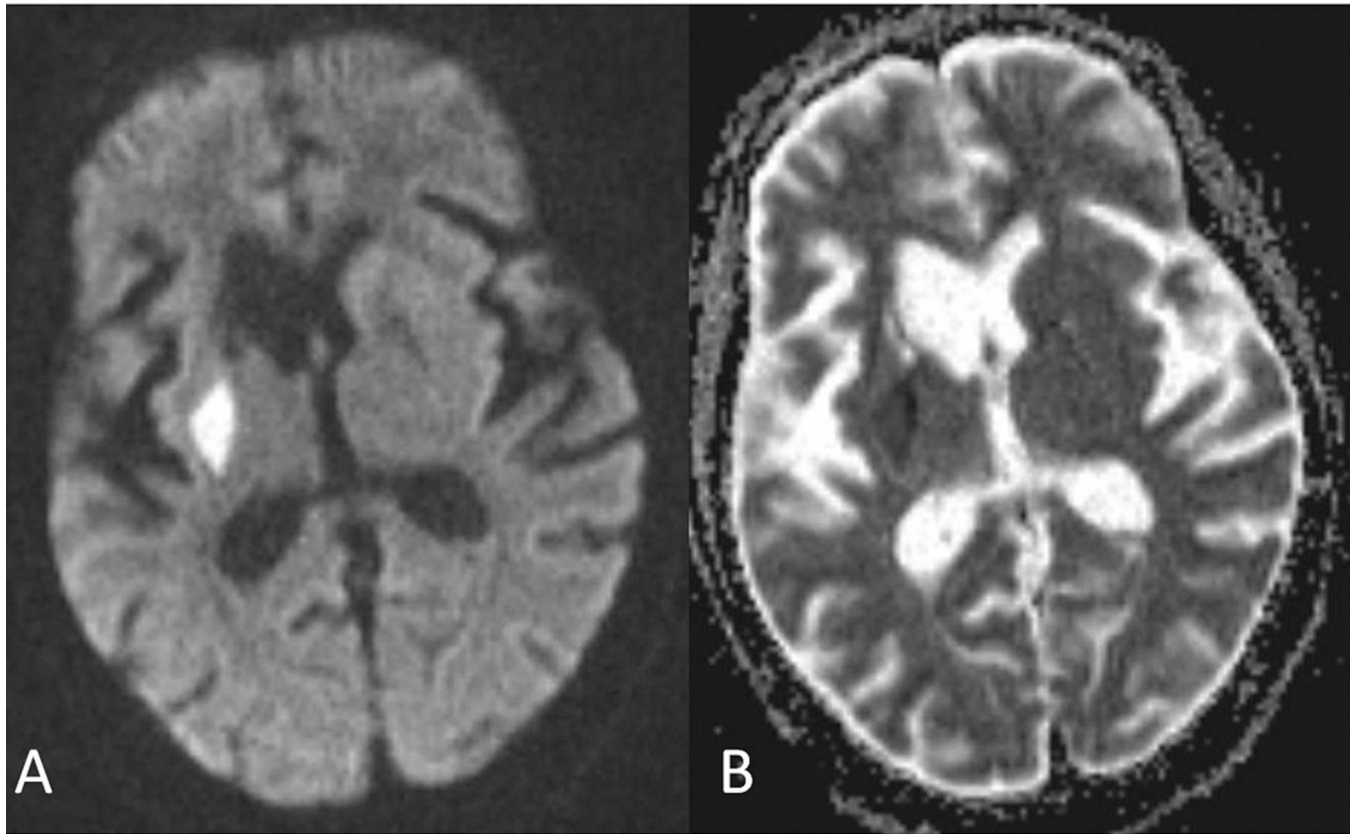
Patient #8. DWI (A) and ADC map (B) show an acute infarct in the right basal ganglia with restricted diffusion. There is also an old infarct in the right caudate head with volume loss, increased diffusion and ex-vacuo dilatation of the right frontal horn.
